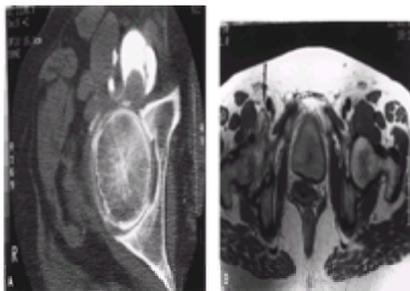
Iliopectineal bursitis/iliopsoas tendinitis. A: This computed tomography arthrogram demonstrates communication between the hip joint and an anterior bursa (arrow). The bursa surrounds the psoas tendon. B: On a magnetic resonance imaging scan the bursa appears as a mass extending anteriorly beneath the femoral artery. Such a mass (arrow) can be palpated and may compress the femoral vein.
